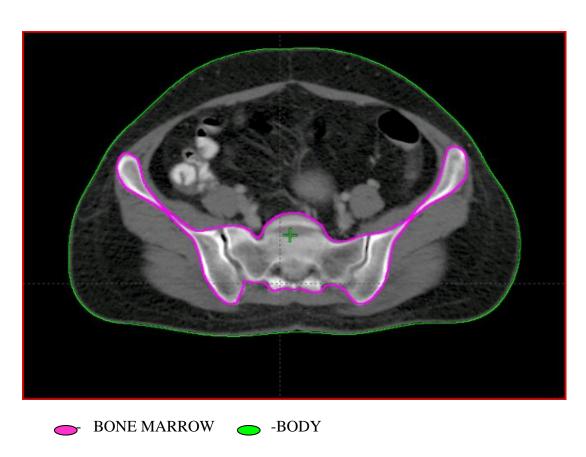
Delineation of bone marrow on CT scan
